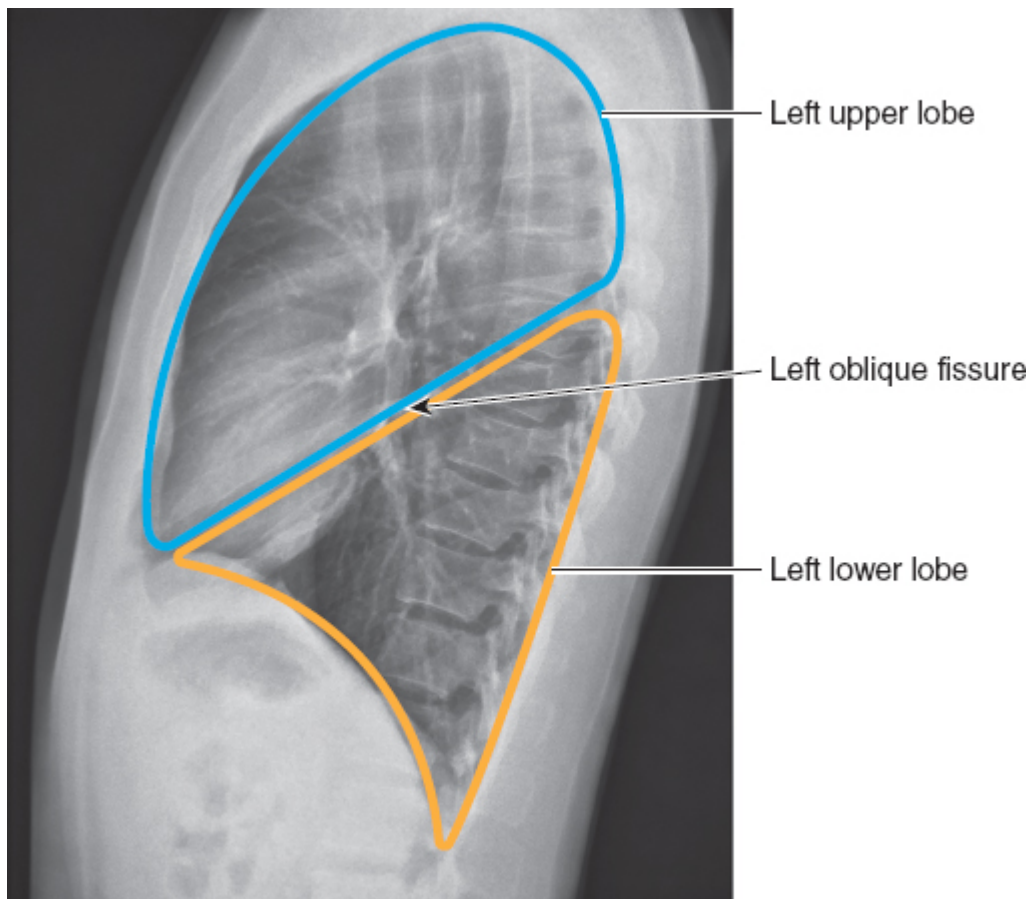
Lobes of the left lung in lateral view of a chest radiograph. (Modified from Brant WE, Helms CA. *Brant and Helms Solution: Fundamentals of Diagnostic Radiology*. 3rd ed. Lippincott Williams & Wilkins; 2007, [Fig. 21-2](#).)
